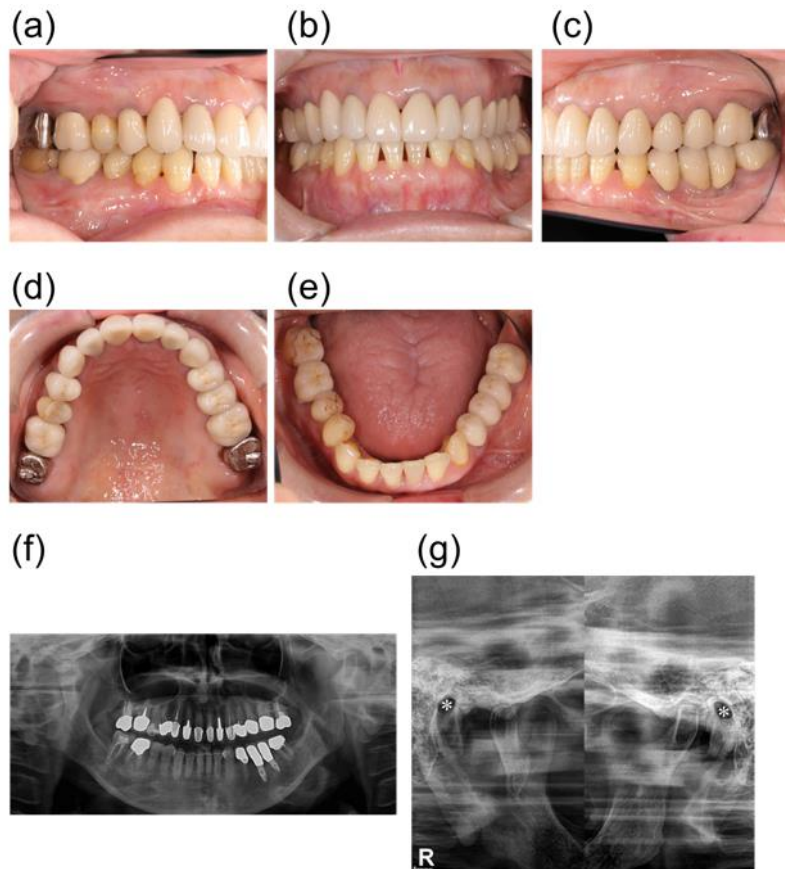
Intraoral photographs and radiographs. A) Right molar relationship, B) frontal view, and C) left molar relationship in centric occlusion. D) Upper and E) lower occlusal view (flipped mirror image). F) Panoramic radiograph. G) TMJ radiographs at closed mouth position. Asterisks: The external auditory foramens.
